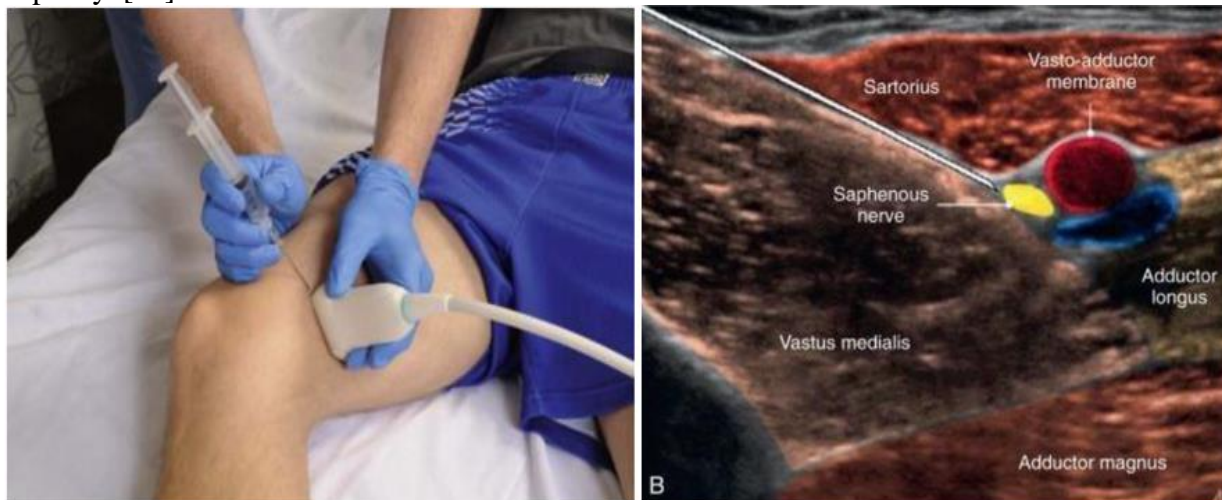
Technique and Ultrasound of adductor canal block [35]
